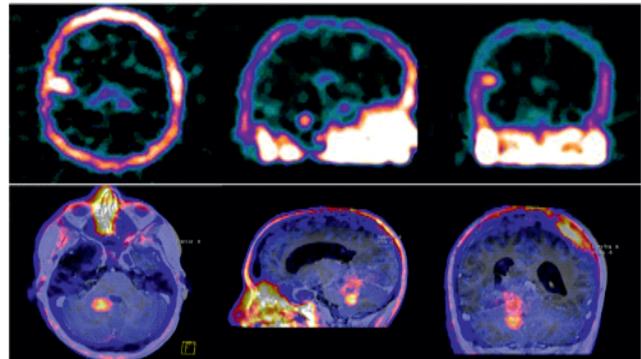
Nuclear Medicine techniques: a) Brain SPET (from the University Hospital of Larissa), b) Brain PET, fused with MRI (courtesy of V. Prassopoulos, PET-CT Department, Hygeia Hospital, Athens).
